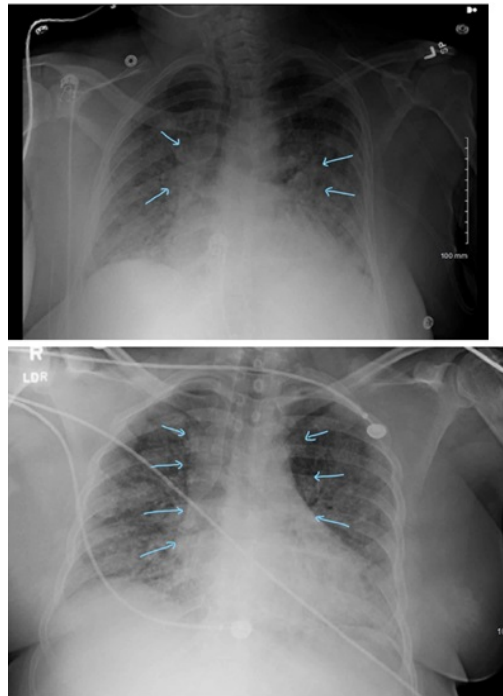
Chest X-ray showing bilateral GGO with worsening aeration suggestive of ARDS (arrows).
